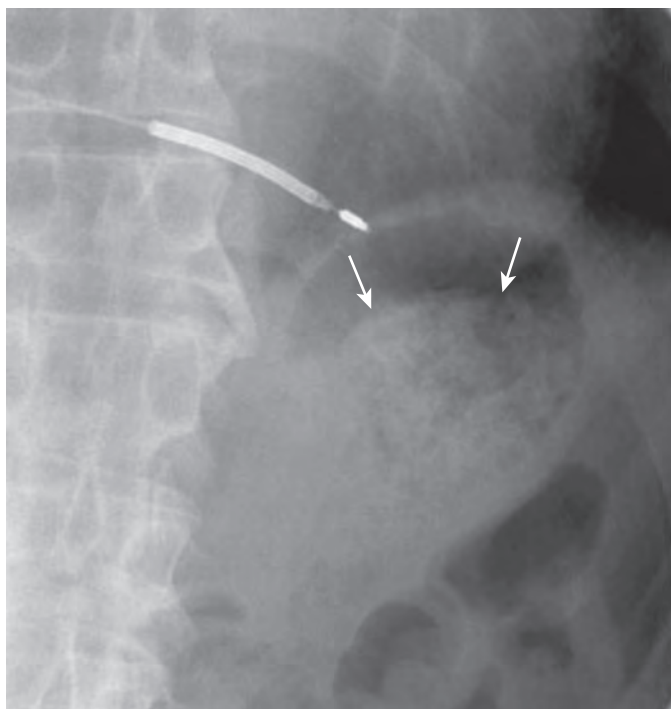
Gastric bezoar. Supine abdominal radiograph shows a gastric bezoar as a mottled soft tissue mass (arrows) floating in the stomach at the air-fluid interface.
